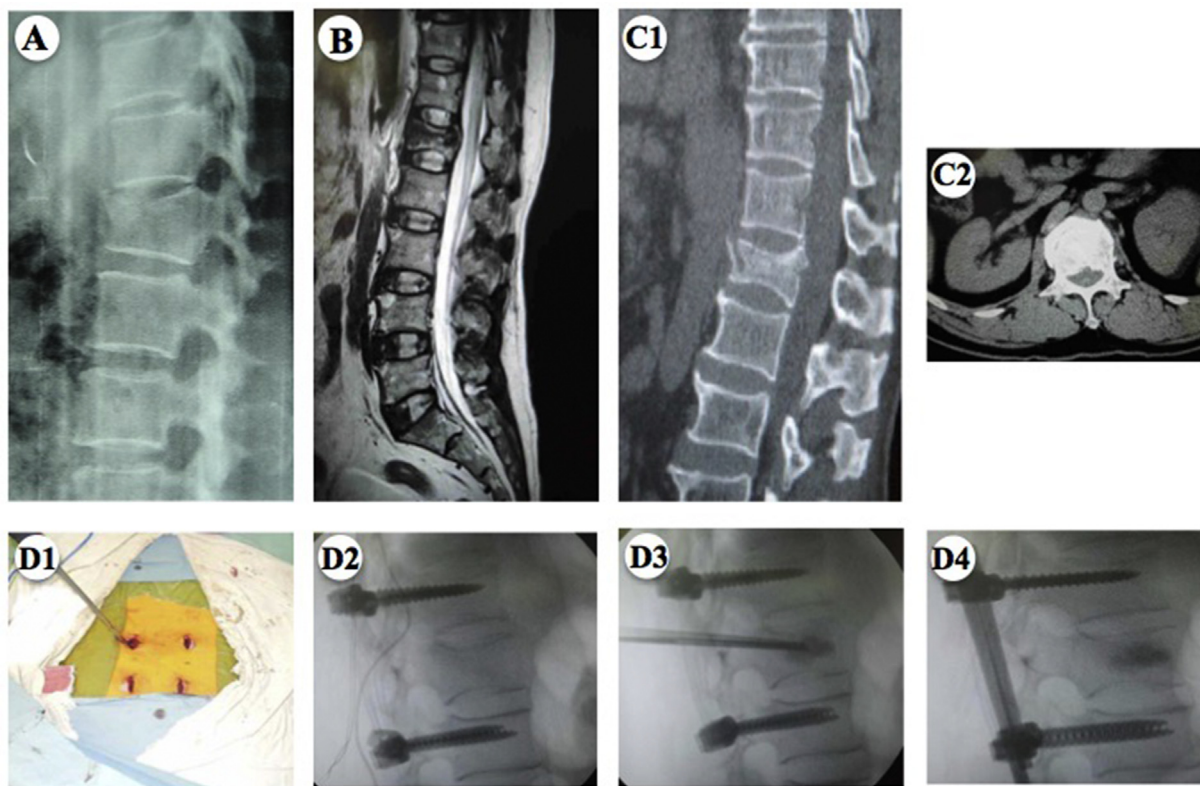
Pre-operative (A) lateral X-ray, (B) MRI, and (C1) CT showed a type A3.1 L1 fracture. Pre-operative (C2) axial CT showed no neurological compression. (D1) Photograph and (D2) fluoroscopic image showed placement of pedicle screws into the vertebrae adjacent to the fractured one using a minimally invasive technique. (D3) Fluoroscopic image showed the injection of bone cement after insertion of minimally invasive pedicle screws. (D4) Fluoroscopic image showed the placement of rods over the pedicle screws in adjacent vertebrae.
